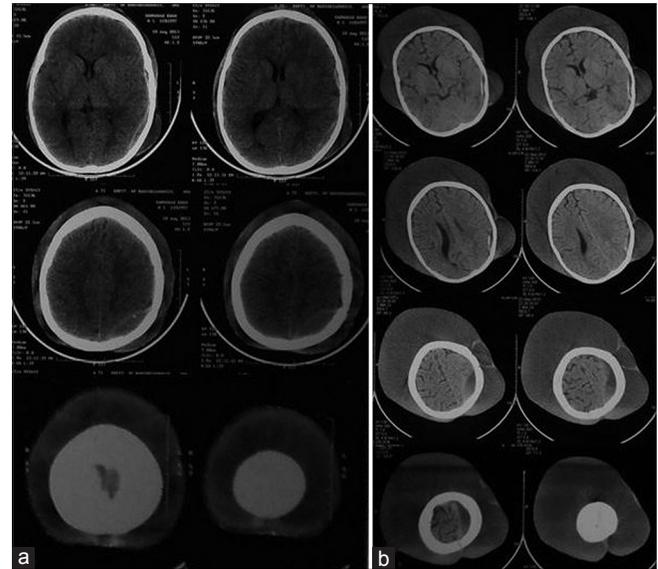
(a) Computed tomography (CT) head plain done at 5 days after trival trauma showing left parieto-occipital extradural hematoma and massive circumferential extracranial hypodense scalp collection. (b) Repeat CT head plain done at 30 days after trival trauma showing increase in circumferential extracranial hypodense scalp collection and resolving left parieto-occipital extradural hematoma
